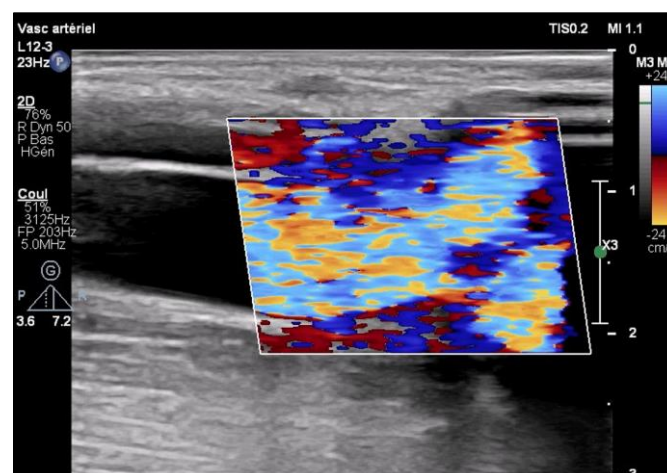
Color Doppler ultrasound of the right upper limb noted Aliasing at the fistula site
